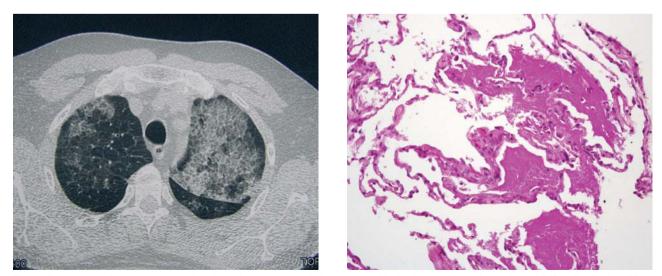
Chest computed tomography scan that shows the typical ground-glass pattern with alveolar opacities and a patchy and diffuse distribution of linear septal thickening. The lower part shows details of the transbronchial biopsy where it can be seen that the alveolar spaces are filled with an eosinophilic and acellular material that had a positive periodic acid-Schiff reaction (3 washes, 20 minutes each).
